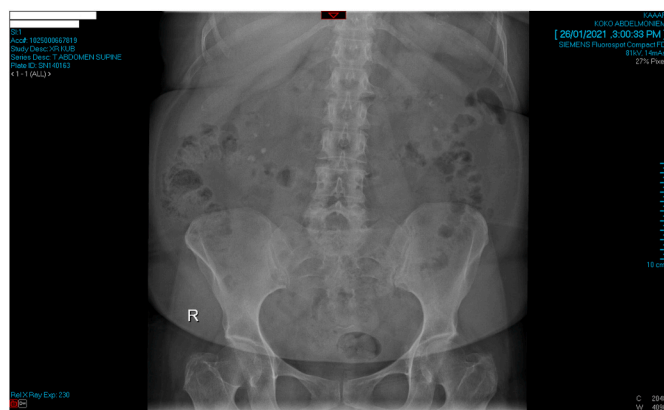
Plain X-Ray KUB demonstrates multiple bilateral radiopaque shadows seen at the region of both kidneys likely representing renal calculi (pre-SWL).
